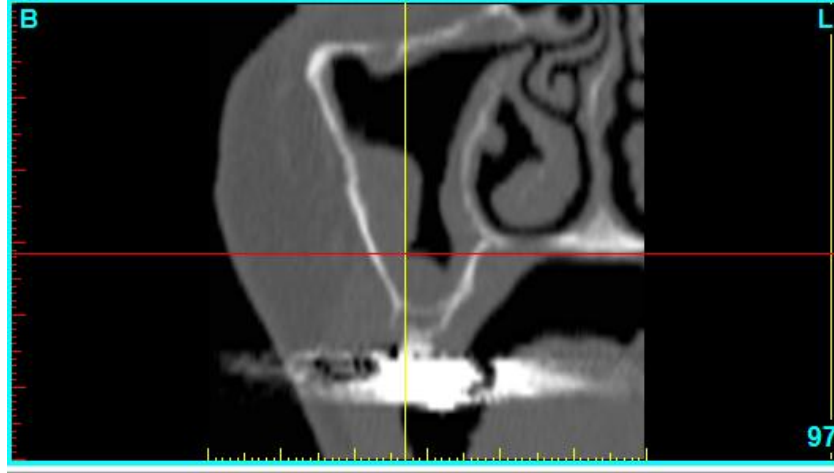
Sagittal view of a CT scan demonstrating mucosal thickening.
